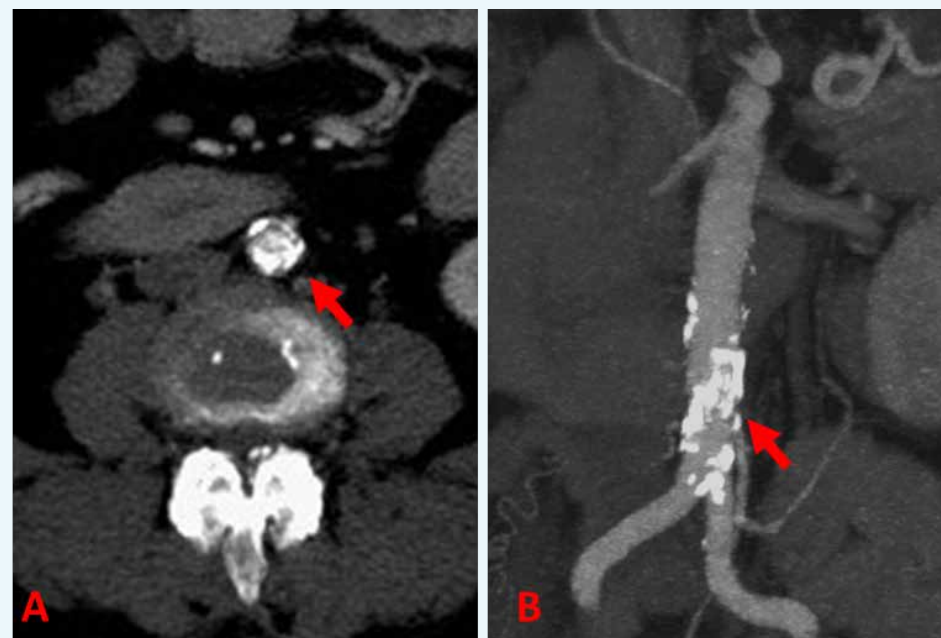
Preoperative CT arteriogram demonstrate a bulky, heavily and circumferentially calcified obstruction in the infrarenal abdominal aorta (A). On MIP reconstructions (B), the plaque is seen as focused within the infrarenal segment extending to the bifurcation, but sparing the iliac vessels.
